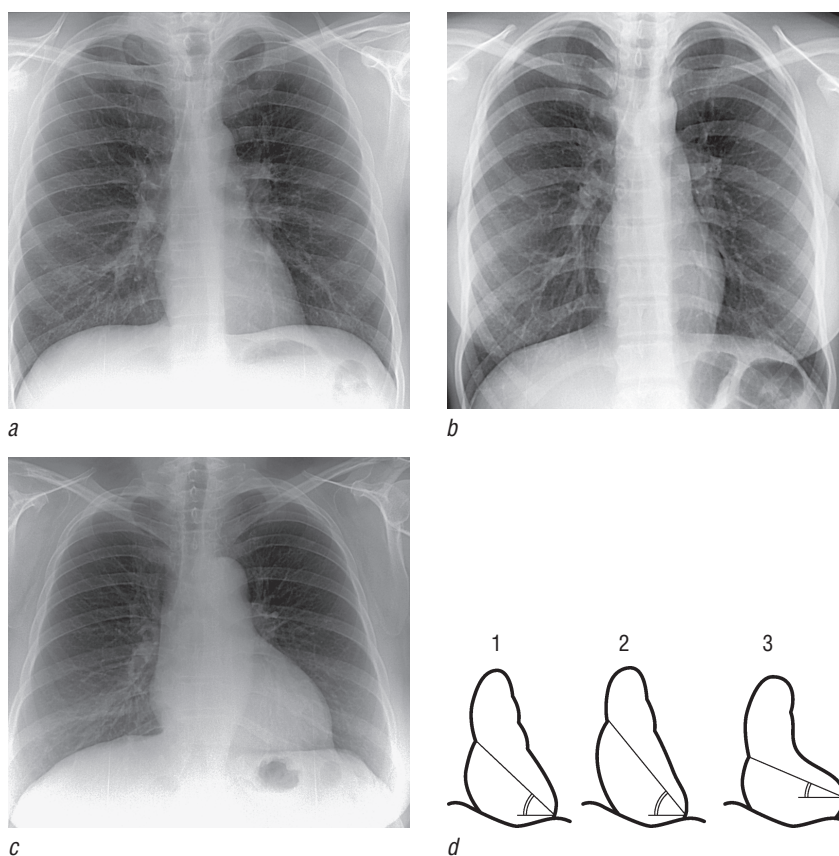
Frontal chest X-ray with different heart positioning due to the constitutional type: *a* — normosthenic; *b* — asthenic; *c* — hypersthenic; *d* — schemes (1 — normosthenic, 2 — asthenic, 3 — hypersthenic)
